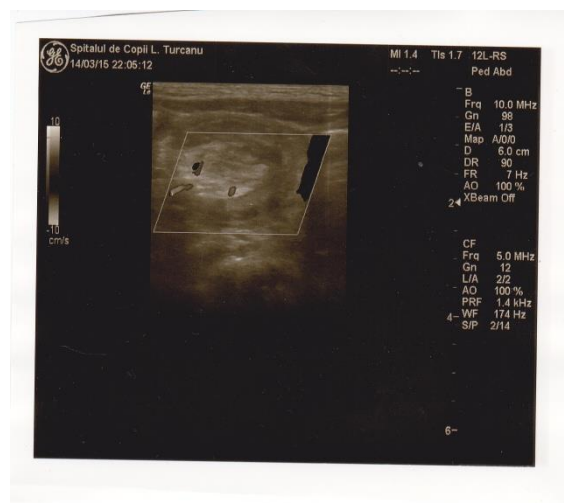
Doppler ultrasound of the intussusceptions showing adequate perfusion.
